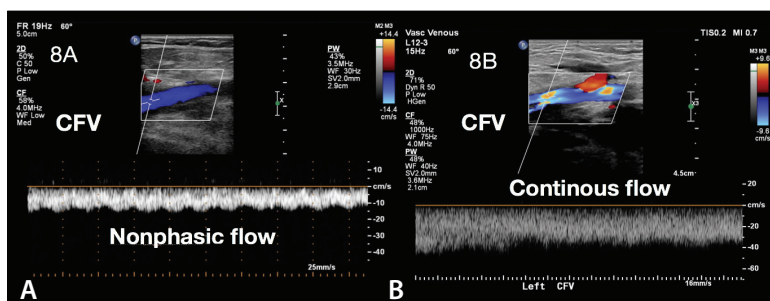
CFV nonphasic pulse Doppler waveform obtained from a 53-year-old woman with hyperpigmentation at both ankles (A). Duplex ultrasound revealed a 14- X 12- X 21-cm uterine tumor causing vein compression. A continuous pulse Doppler flow pattern was identified at the CFV level in a patient with significant left-sided postthrombotic disease (B).
